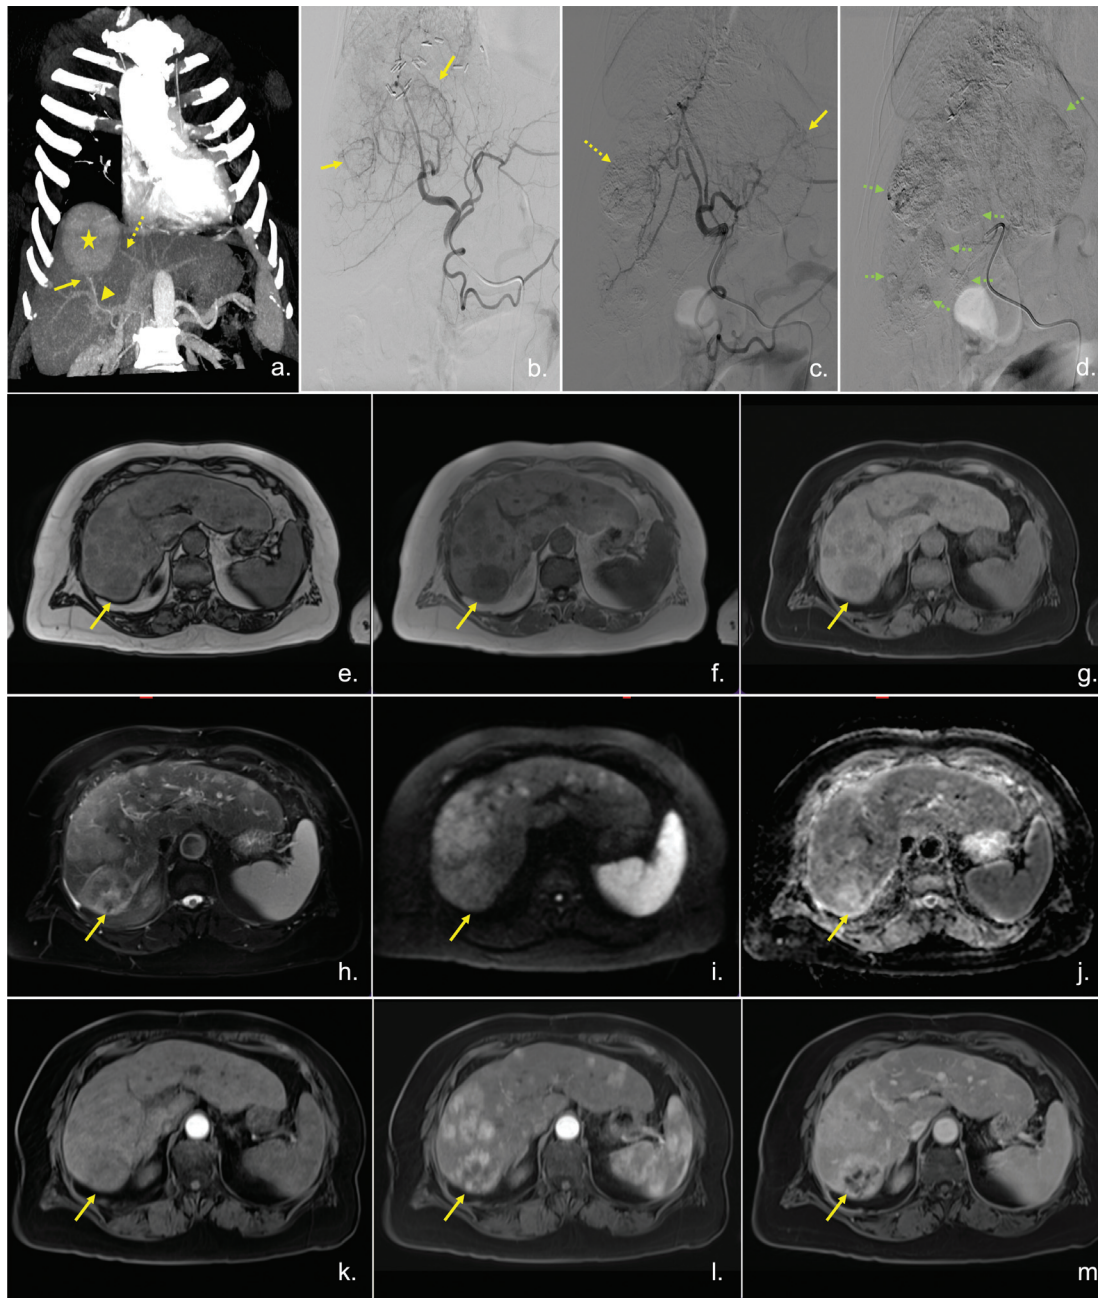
A 77-year-old cirrhotic patient, Child–Pugh B–7 points, ECOG 2, BCLC-B, known multinodular HCC, previous partial hepatectomy, no esophageal varices, no ascites, no encephalopathy. Received management with TACE shown below but had poor response. In controls, it was documented deterioration of liver function without possibility of being considered for additional interventions and was candidate for management by palliative care. (a) In this last intra-arterial treatment only CT angiography was considered pre-TACE: arrowhead points out right branch of the hepatic artery. Interrupted arrow points out left portal middle branch. Asterisk marks out Hepatocellular carcinoma already known which had 7.6 cm of maximum diameter. (b–d) Three months later, TACE was scheduled: Catheterization and selective angiography of the right hepatic artery was done and multiple hypervascularized lesions of different sizes are defined. They infiltrate whole right hepatic parenchyma. Administration of mixed doxorubicin and lipiodol is performed until a decrease in the flow of the right arteries and opacification of the multiple nodules was obtained (green arrow in “d” picture points out embolized hepatocarcinoma lesions). (b) Arrows indicate vascularization that circumscribes neoplastic lesions. (c) Continuous arrow indicates a nonembolized lesion and the discontinuous arrow indicates an already embolized lesion. (e–m) Selected images in 2-month control MRI where multiple focal lesions of hepatocarcinoma were present. The lesion marked out with yellow arrow in each picture corresponds to the lesion pointed out with an asterisk in the picture “a” in the liver segment VII. mRECIST was not possible to be calculated because it was considered noncomparable pre- and post-TACE imaging modality (first was CT angiography and post-TACE it was MRI); therefore LI RADS was reported, which was considered LR-TR viable due to focal lesions in segment VII considered with findings of embolization and persistence of viable tumor and multiple not measurable lesions suggestive of hepatocarcinoma (e: T1 out of phase, f: T1 in phase, g: T1 fat sat, h: T2 fat sat, i: diffusion, j: ADC, k: early arterial phase, l: arterial phase, m: portal phase).
